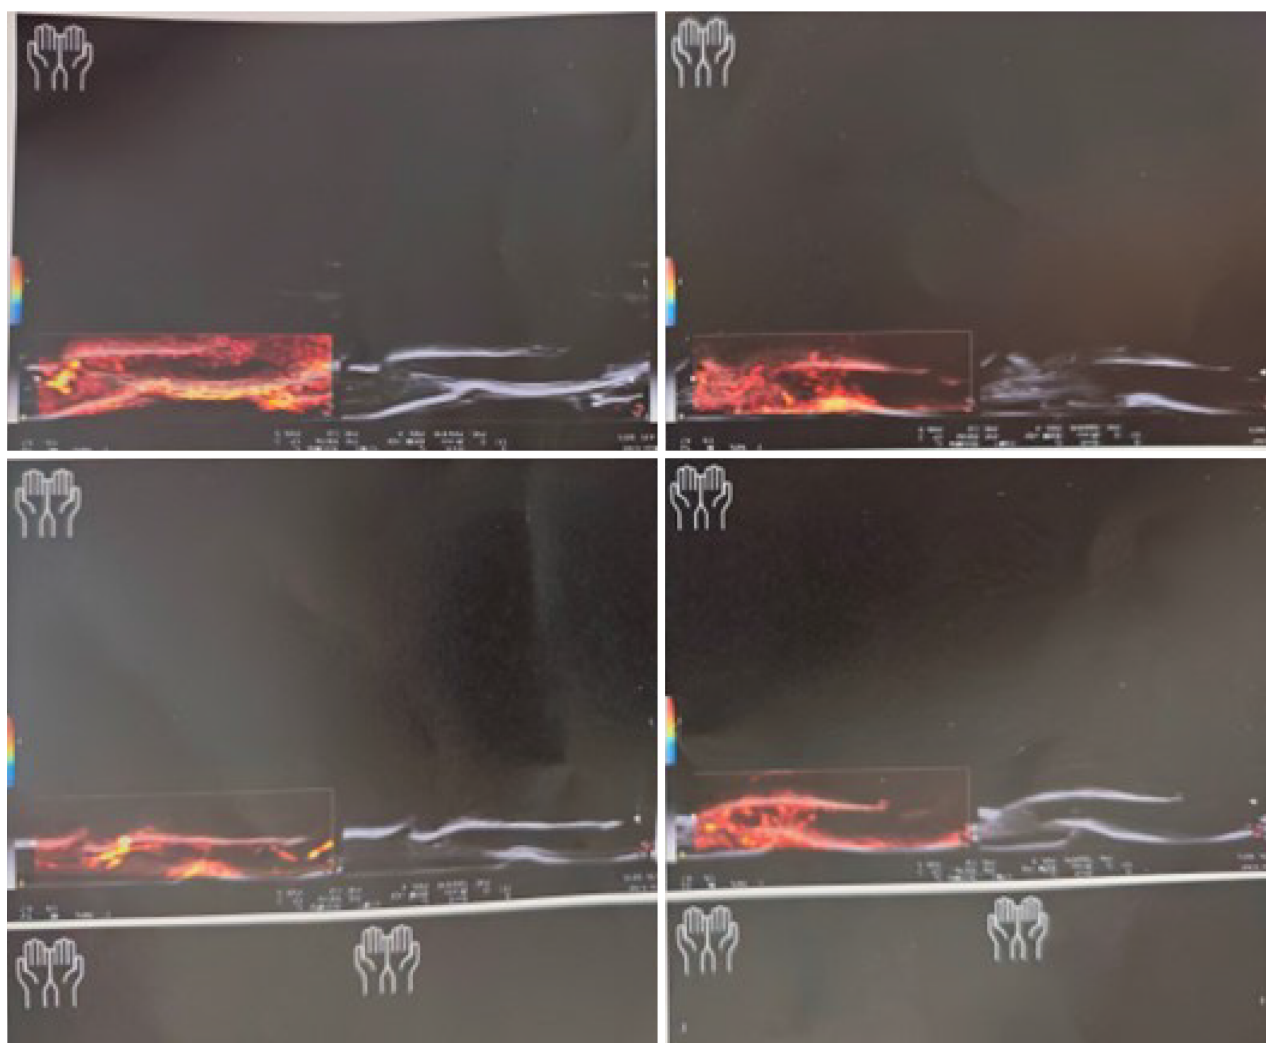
Ultrasound image with positive Doppler signal at the nail entheses of the left hand's third and fourth fingers.
